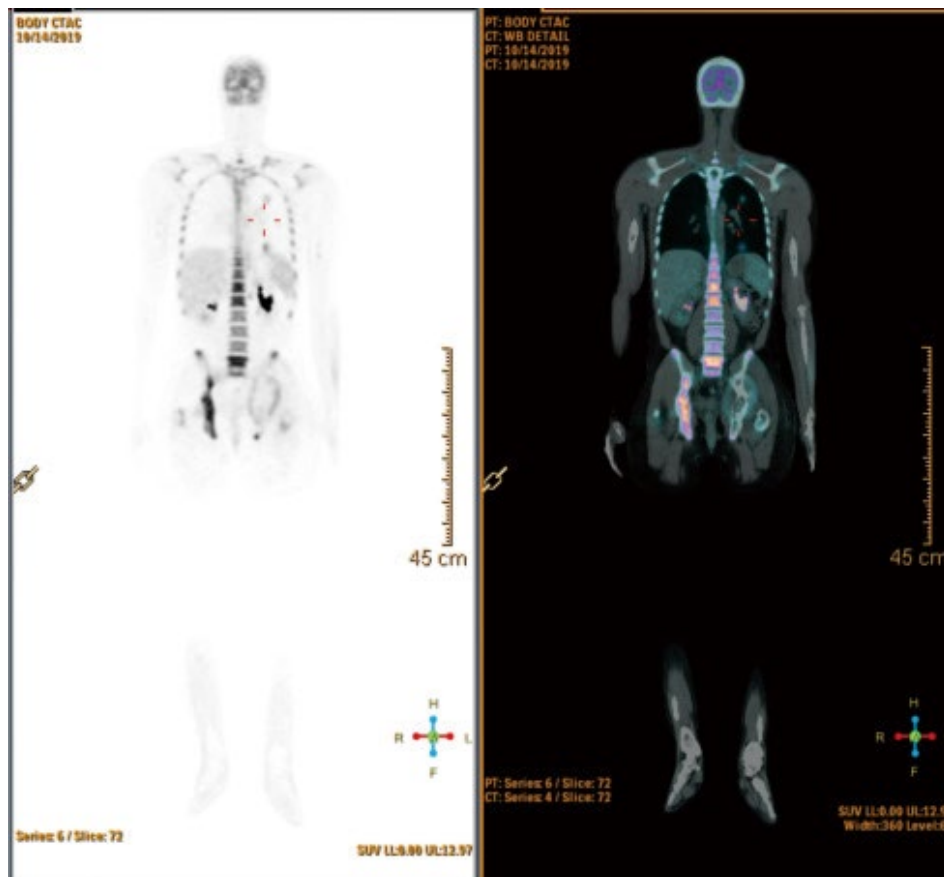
Positron emission tomography-computed tomography images show signs of neoplastic activity on the spine and acetabulum, in addition to pulmonary nodules.
